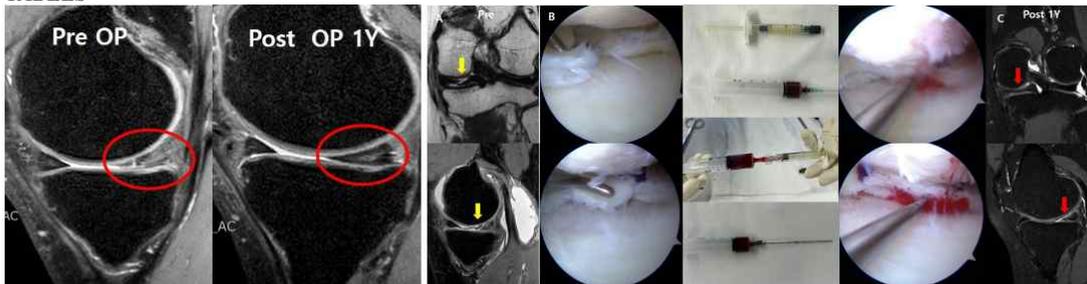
Case 1: A 56-year-old female presented with posteromedial joint line pain for over 9 months. Arthroscopic evaluation revealed a radial-horizonal complex tear of the medial meniscus. The tear was repaired using a suture hook and four stitches with PDS-0, along with the application of a blood-collagen mixture. On 1-year follow-up MRI, the medial meniscus showed near-complete healing.
